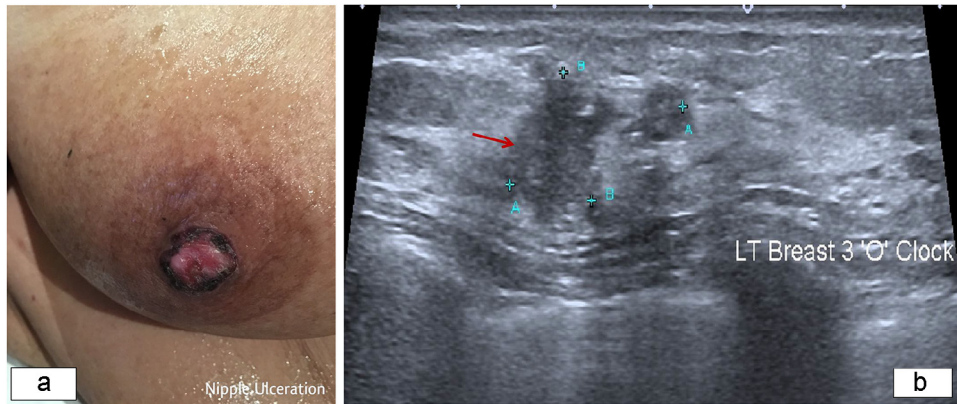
(A) Clinical image of the right breast showing nipple ulceration. (B) Ultrasound image showing an irregular, ill-defined hypoechoic lesion measuring approximately 2.0×1.1 cm at the 3-o' clock position, circle 1, zones B and C of the left breast (arrow).
